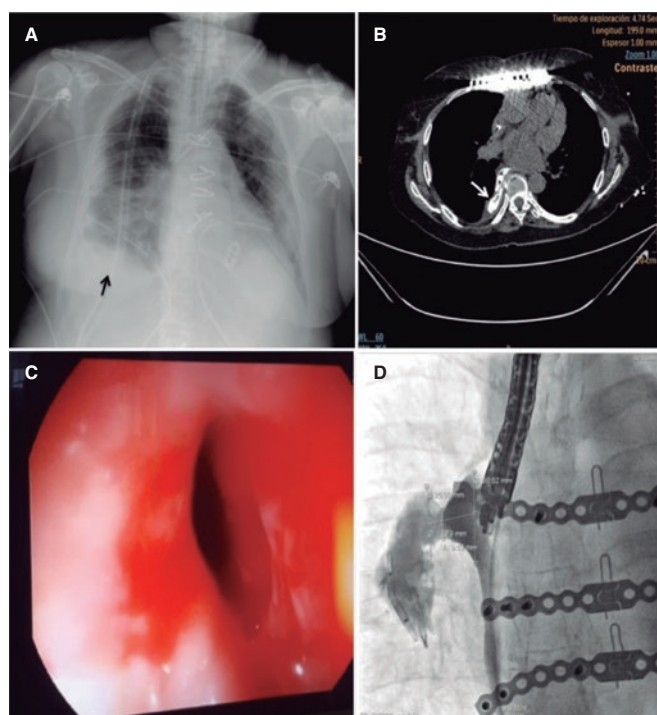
A: X-Ray image showing right pleural effusion (arrow). B: computed tomography scan with oral contrast, the axial section shows extravasation of contrast to the pleural space (white arrow). C: endoscopic image of the perforation after transesophageal echocardiography. D: fluoroscopy with oral contrast showing the morphology and measurements of the esophageal-pleural fistula.
